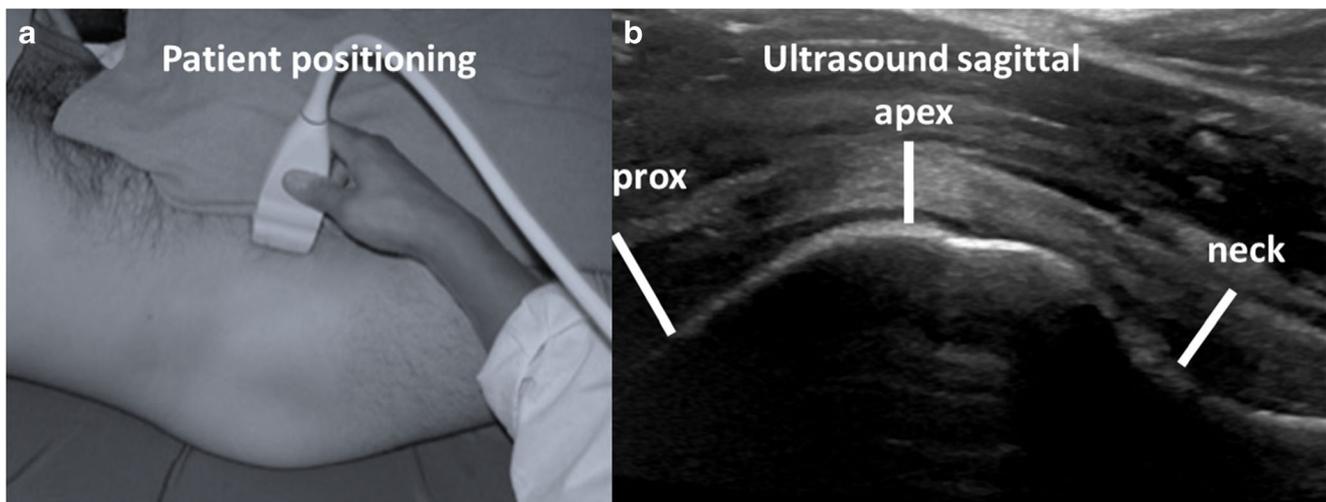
a Patient and probe positioning for ultrasound. b Bone-to-capsule distance (BCD) measurement of effusion synovitis on ultrasound. *prox* proximal
